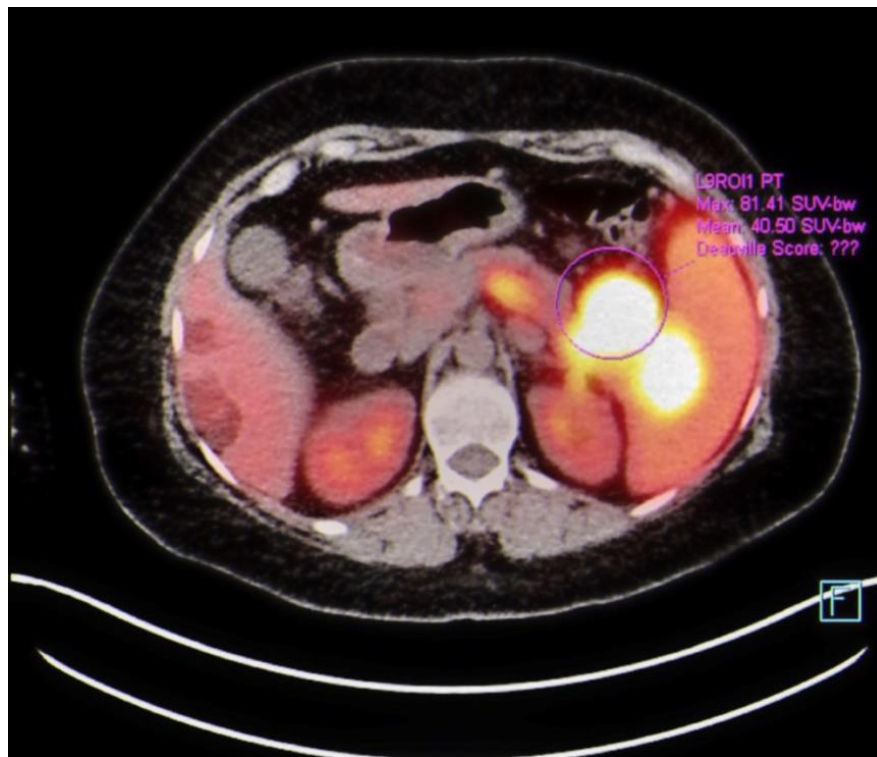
The image shows a large splenic lesion measuring about 3.7 x 3.6 cm in maximum axial dimensions with SUV max 64.3, in addition to a large soft tissue mass lesion within the tail of the pancreas measuring about 4.8 x 2.5 cm in maximum axial dimensions, exhibiting abnormal DOTATOC uptake with SUV max 83
